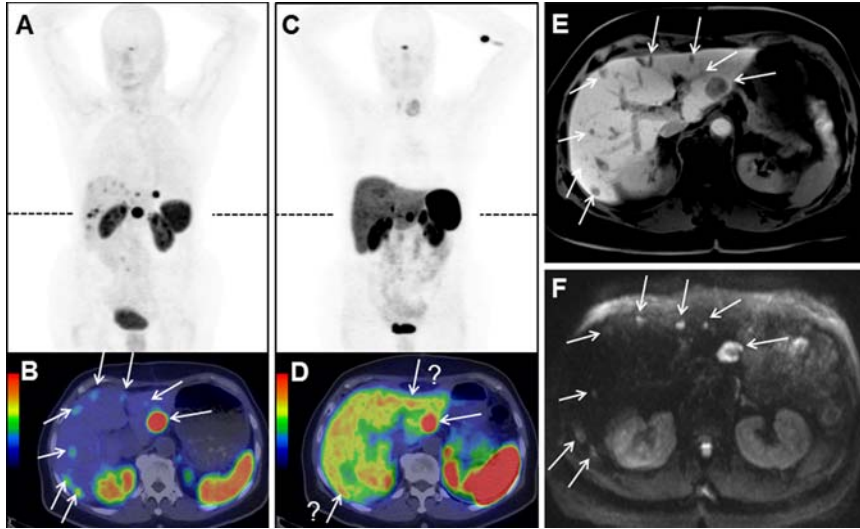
^{68}Ga -OPS202 PET/CT (50 μg) (A, B), ^{68}Ga -DOTATOC PET/CT (C, D) both 1 h post-injection and MRI (E, F) in patient 9 with an ileal NET, showing bilobar liver metastases. Dotted lines show the level of transaxial slices. PET/CT were performed on the same scanner within 2 months and scans were read using the same gray (MIP) and color scale (transaxial fusion). Findings were correlated with liver MRI performed 4 months after ^{68}Ga -OPS202 PET/CT, with delayed post-contrast acquisitions (E) and diffusion weighted images (F), confirming the additional metastases missed or questionable (arrow with question mark) on ^{68}Ga -DOTATOC PET/CT. Importantly, background activity of ^{68}Ga -OPS202 was lower in the liver, intestine and thyroid than with ^{68}Ga -DOTATOC (e.g. for the liver mean SUVmax was 2.6 vs 10.2). Repeated thyroidectomy for benign goiter failed to demonstrate malignancy of the left thyroid nodule.
